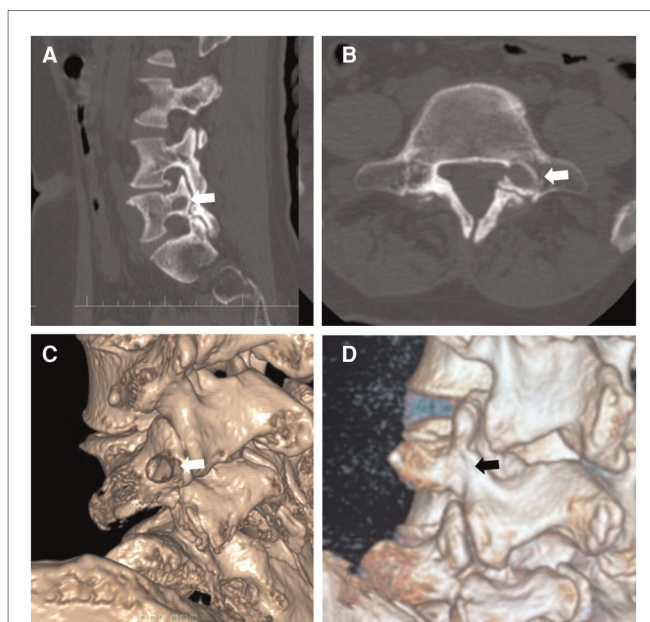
(A) Postoperative computed tomography shows a bone tunnel in the sagittal plane. (B) Postoperative computed tomography shows a bone tunnel in the horizontal plane.
